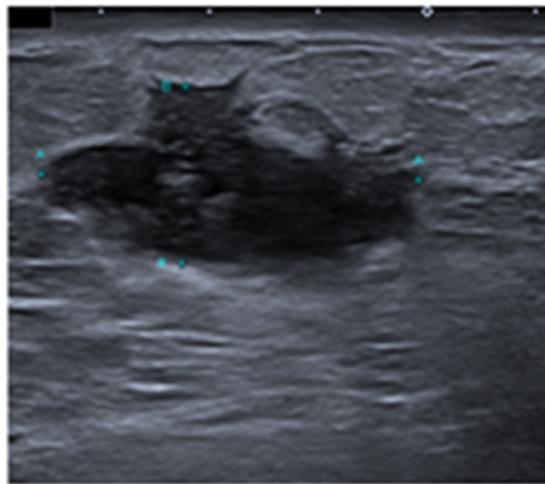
Left breast ultrasound obtained in the retroareolar region showing a heterogeneous hypoechoic mass with angular margins.
